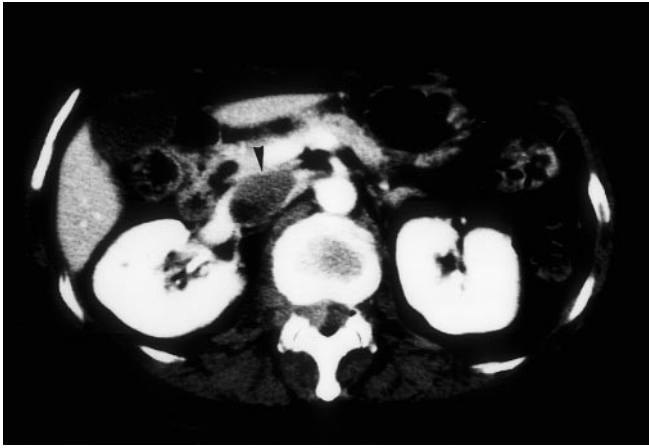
Computed tomography at the renal hilus or coeliac artery level. A luminal and bulky tumour (*arrowhead*) is observed in the dilated inferior vena cava. No tumour is observed in the retroperitoneum
